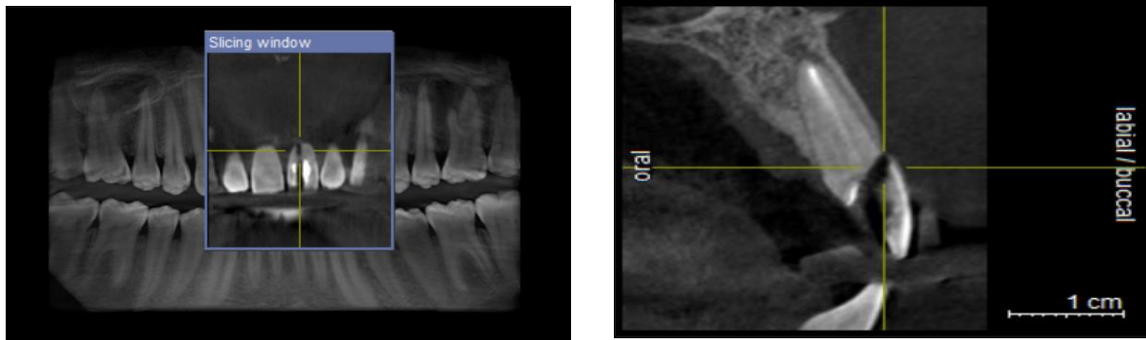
3-D CBCT View A] Panoramic View, B] Axial View
